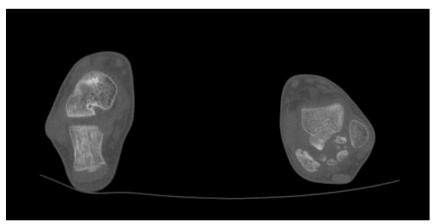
Axial CT: multiple ossifications with the typical central fat attenuation on the medial side of the left ankle, posterior and medially to the talus
